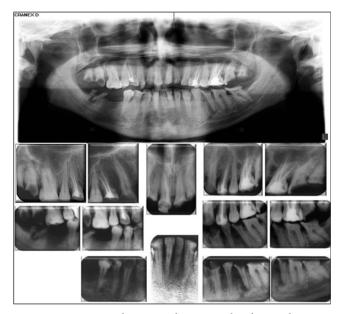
OPG and Intra oral periapical radiographs.
